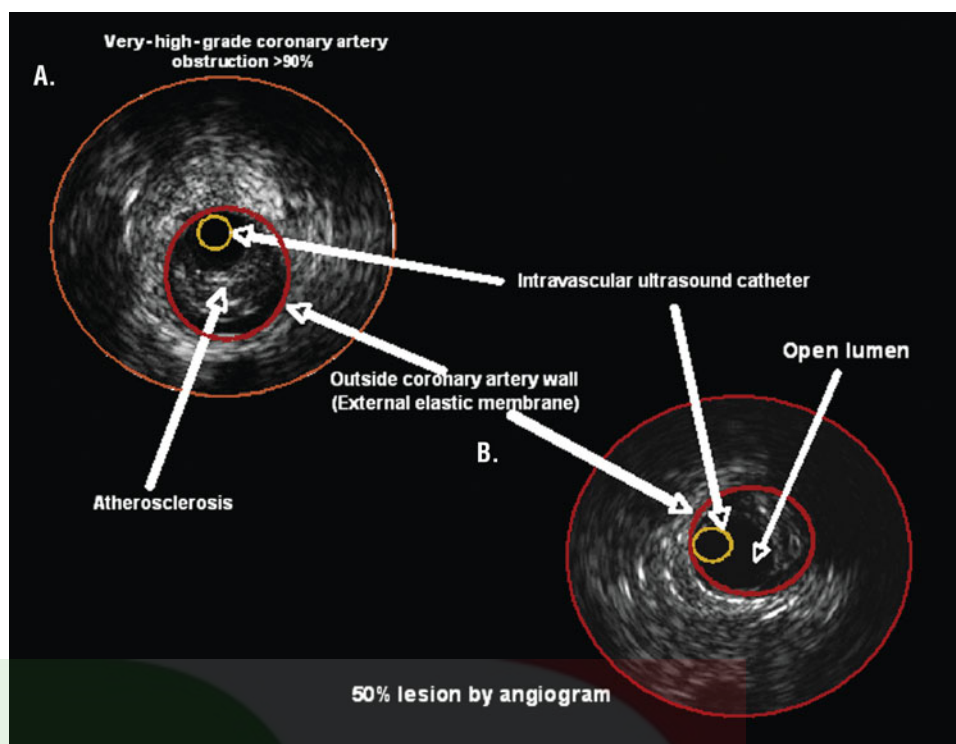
Intravascular ultrasound (IVUS) of a coronary artery. *A.* High-grade obstruction which on angiogram was thought to be only approximately 50% stenotic. *B.* Another coronary artery segment with 50% stenosis but more prone to rupture.
